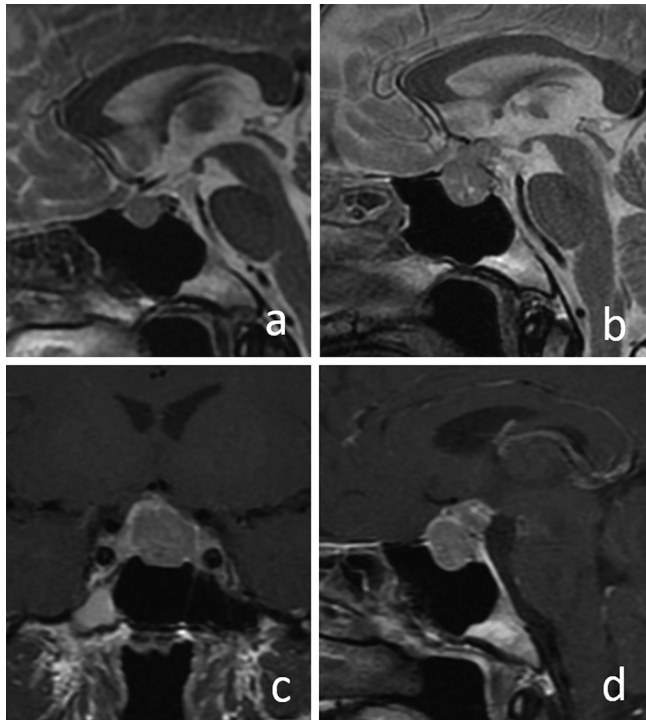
Magnetic resonance imaging (MRI) of 2 months before admission demonstrating a sellar mass which is considered as presence of pituitary adenoma (a). Preoperative MRI showing a significant rapid enlargement over two months; less enhancing pituitary tumor with gadolinium. The tumor compresses the optic chiasma and invades into left cavernous sinus. Normal gland is shifted to the right side (b–d).
